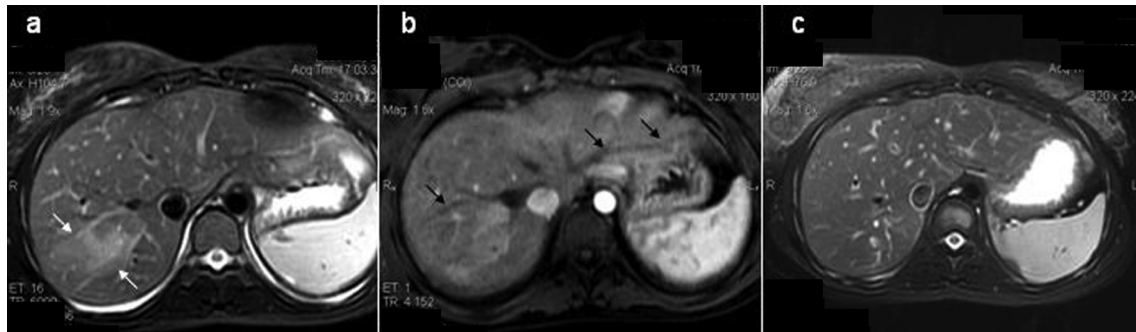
Patient's initial MRI showed a poorly defined heterogeneous area (white arrows) in hepatic segment VII, which presented with high signal intensity on T2 weighted imaging (a). MRI imaging: the most characteristic finding was serpiginous tract lesions (black arrows), beginning from liver capsule and continuing to more central areas of the hepatic parenchyma, which were not enhanced after intravenous contrast media injection, in contrast to their surrounding parenchyma (b). Four months after triclabendazole administration, follow up MRI showed almost complete resolution of the pathological area in the hepatic segment VII (c).
